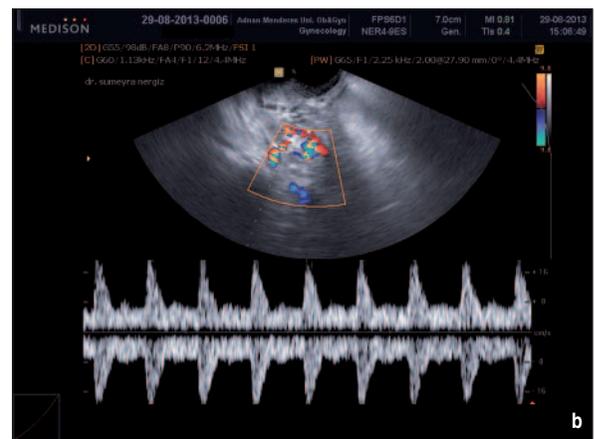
(a) The sagittal endovaginal image of the uterus shows intracavitary lesions in the posterior myometrium. (b) Color and spectral Doppler image shows multiple tortuous vessels with a multidirectional high-velocity, low-resistance flow producing a color mosaic pattern.
